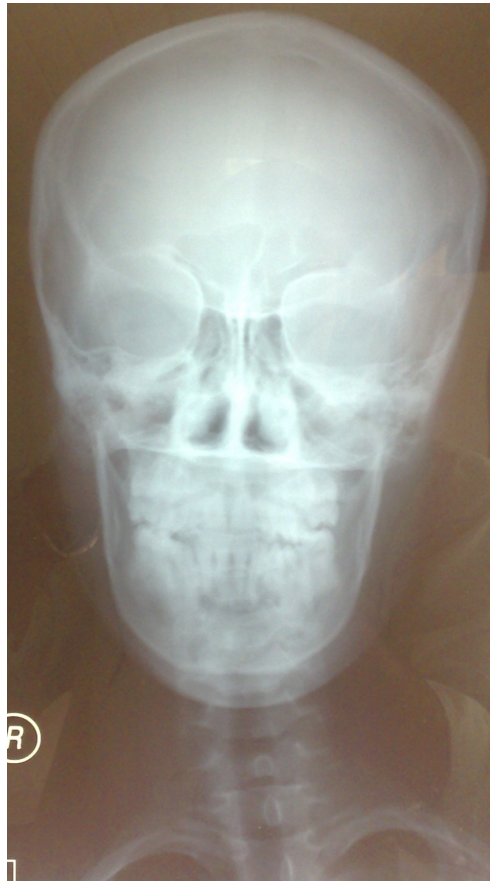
Normal plain X-ray, anteroposterior view of the skull, as part of the skeletal survey.
